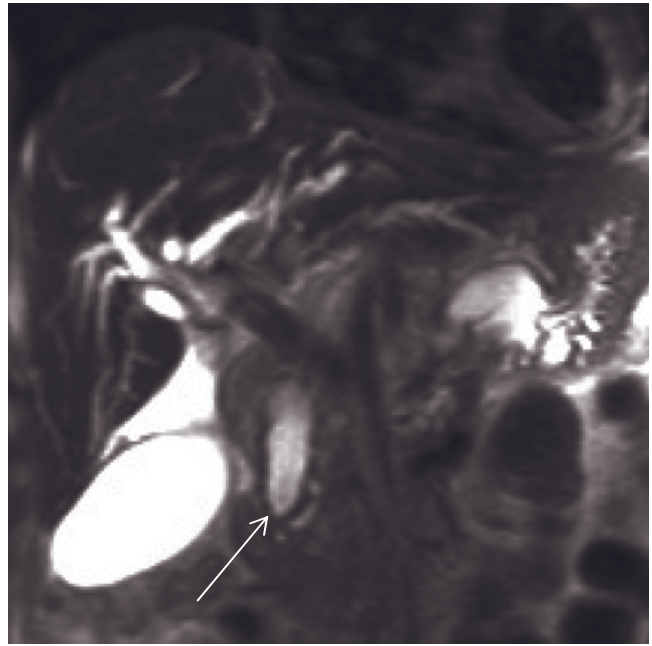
Ampullary fibrosis. Coronal T2-weighted thin-section MRCP single-shot echo-train spin-echo image (a) shows the entire dilated CBD (arrow, a), excluding ductal calculi. Transverse T1-weighted fat-suppressed GE (b) and immediate postgadolinium
